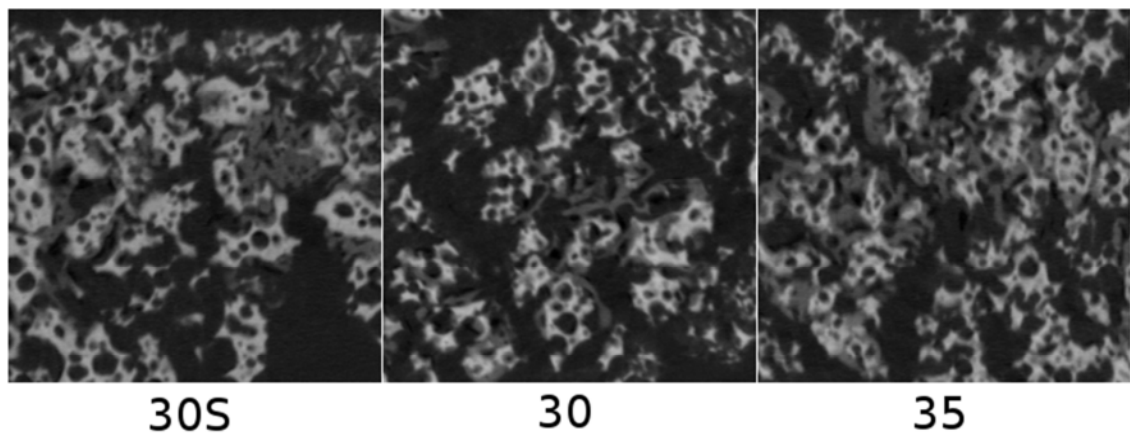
CT slices for all ectopic samples types (30s, 30 and 35).
